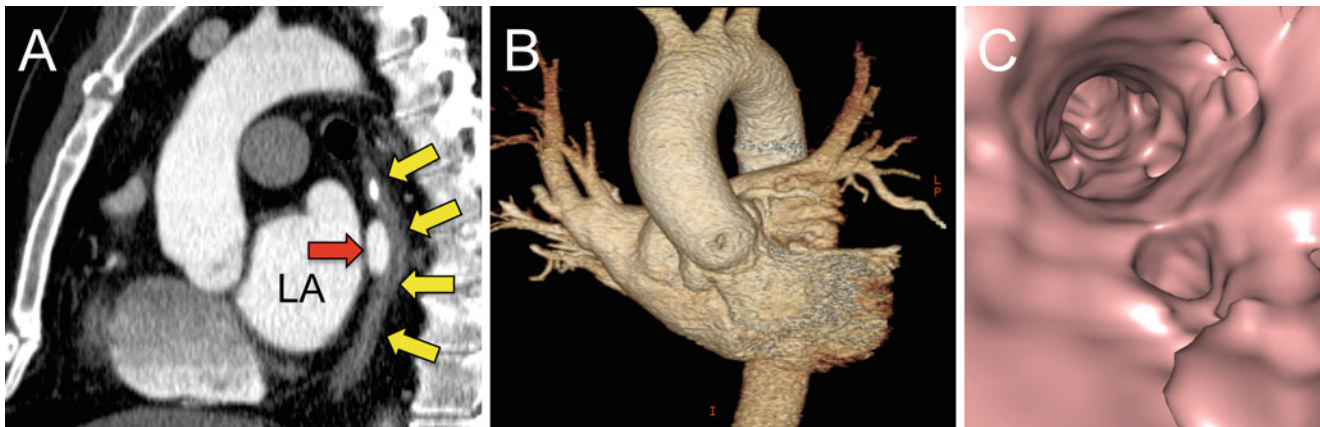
(a) Maximum intensity projection (MIP) CT image with 2-mm slice thickness in an oblique sagittal view shows barium within the esophagus and the location of the esophagus (yellow arrows) with respect to the left atrium and left inferior pulmonary vein (red arrow).
